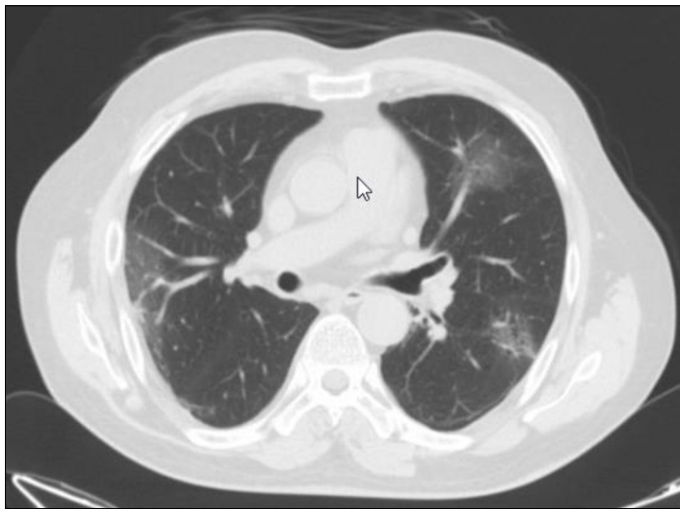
Thoracic computerized tomography (CT): Viral pneumonia representing diffuse ground glass infiltrations.
